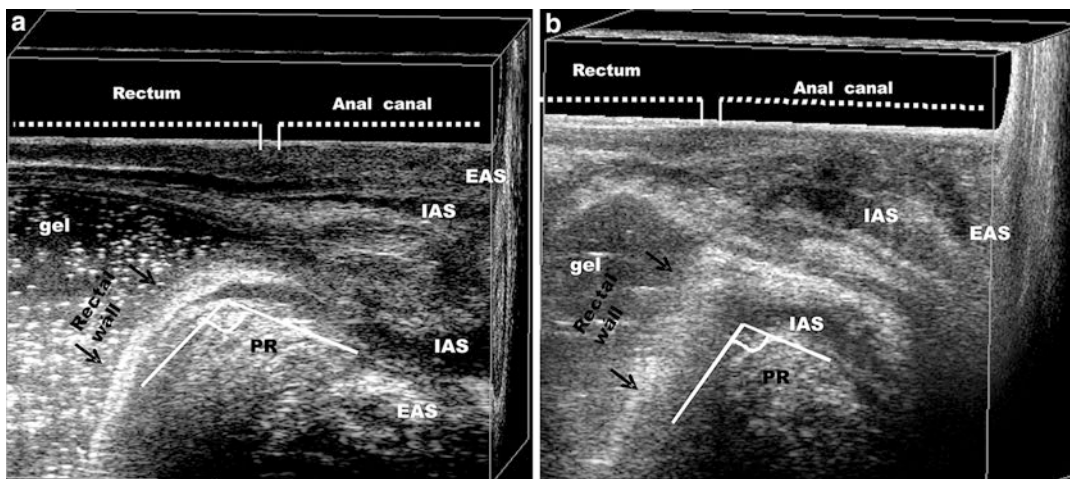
Dynamic 3-D transvaginal and transrectal ultrasonography (TTUS). Using gel into the rectum – Transvaginal approach (a) Angle measured at rest position
